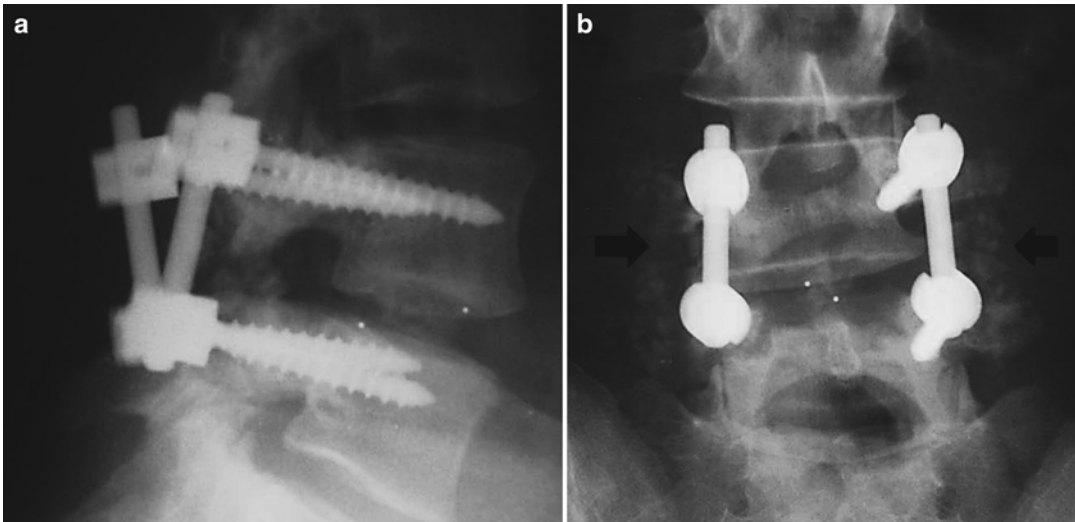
(a) Lateral radiograph of an instrumented posterolateral fusion. Radiolucent markers demonstrate the borders of the interbody device; (b) AP radiograph. *Arrows* point to posterolateral fusion mass
